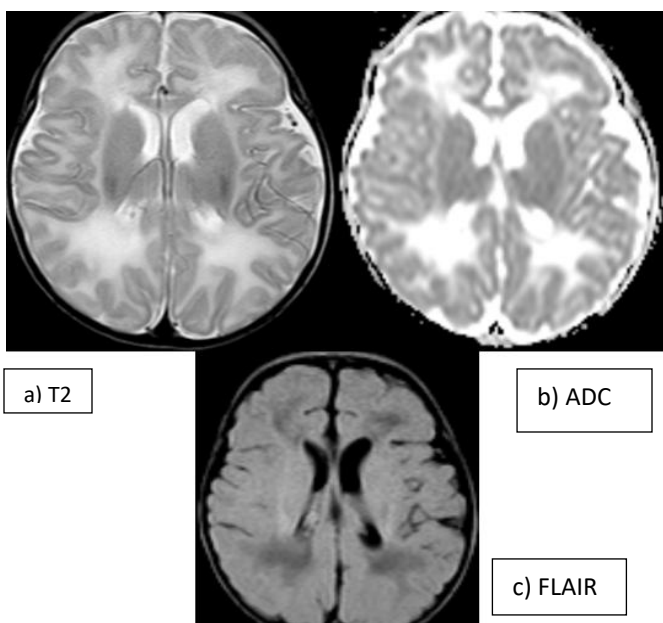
Axial T2 , ADC and FLAIR images showing peri-ventricular leukomalacia changes
